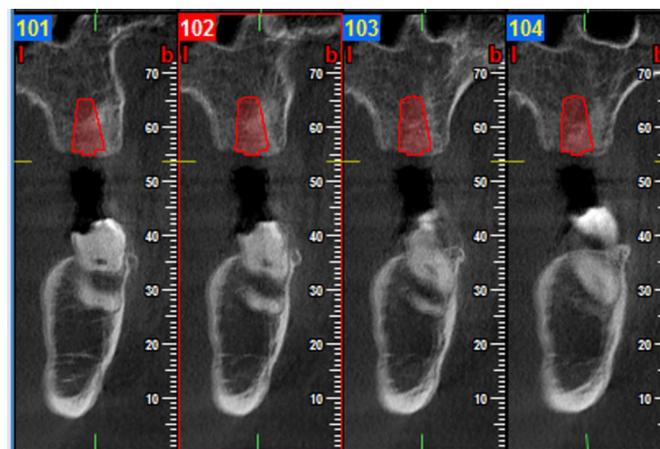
Pre-implant CBCT examination. NNT Viewer software (NewTom, Verona, Italy) allowed to visualize implant in the alveolar ridge and to determine orientation, diameter and length of the proposed implant. A 6 × 10 mm implant (Zimmer Dental Trabecular Metal®) was chosen. Trabecular bone appeared loose. Bone hypertrophic abnormalities were notable on the lingual side of the mandible.
